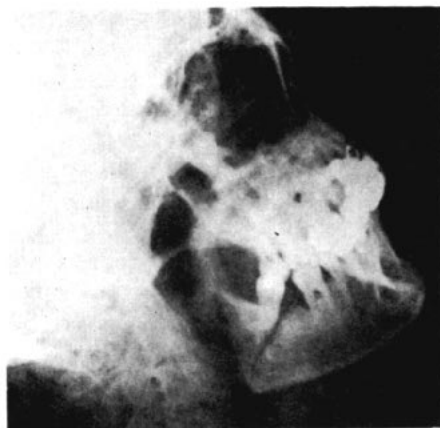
Photograph of the x-ray showing fracture at the angle of the mandible.
